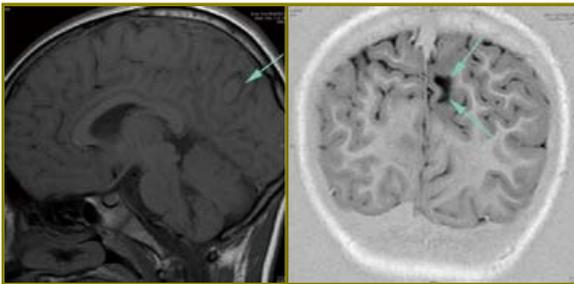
MRI brain of a teenager with refractory epilepsy showed suspected Focal Cortical Dysplasia at left cuneus.
